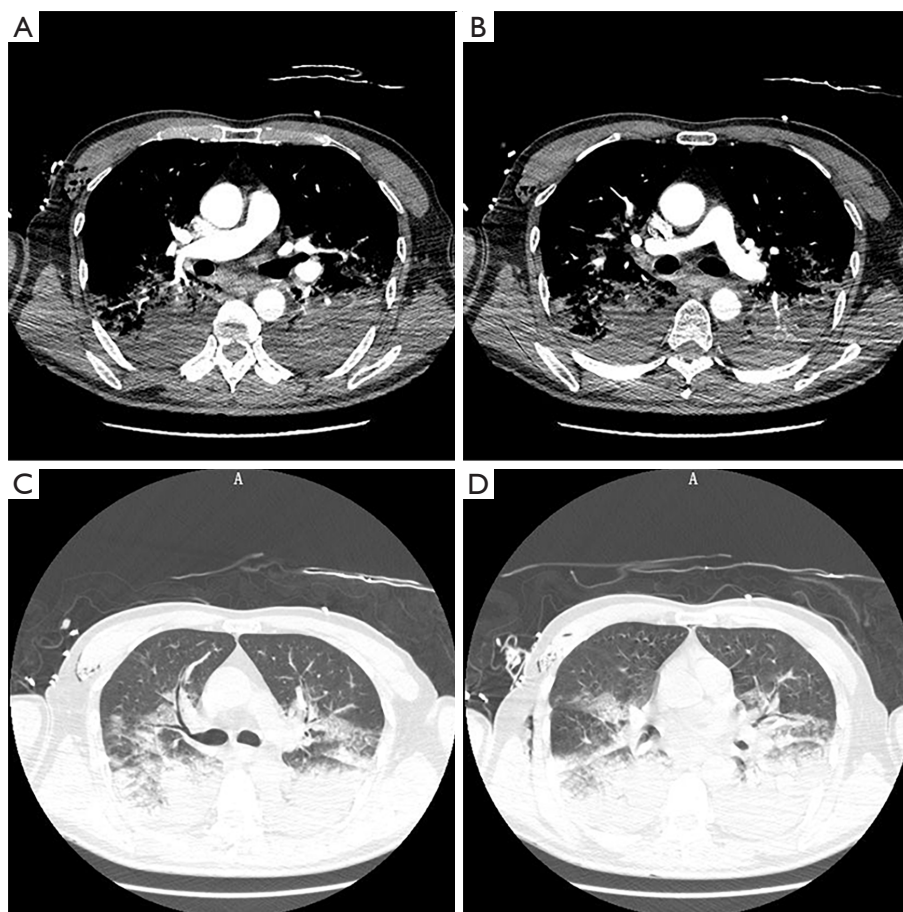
CTPA findings 12 hours after CO₂ embolization. (A,B) Normal filling of both pulmonary arteries, no emboli seen. (C,D) Edema and exudate in both lower lungs. CTPA, computed tomography pulmonary angiogram; CO₂, carbon dioxide.
